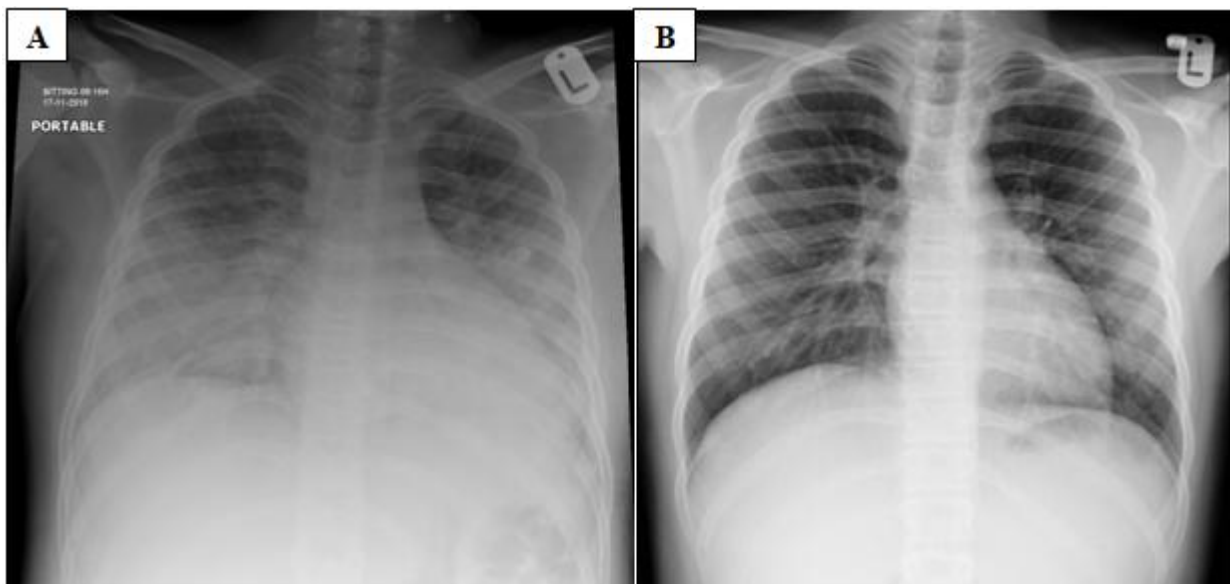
(A) Chest radiograph 2nd day during admission, shows prominent cardiomegaly with progressive opacity over both lower lungs. (B): No abnormal valvular disease
